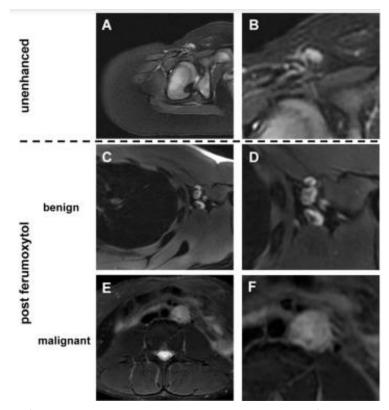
Morphology of benign and malignant lymph nodes on T2-weighted fast spin echo images. A and B represents the unenhanced images, C and D post Ferumoxytol images of benign lymph nodes, E and F post Ferumoxytol images of malignant ones Adapted from: Muehe AM, Siedek F, Theruvath AJ, et al. Differentiation of benign and malignant lymph nodes in pediatric patients on ferumoxytol-enhanced PET/MRI. Theranostics. 2020;10(8):3612-3621. Published 2020 Feb 18. doi:10.7150/thno.40606
